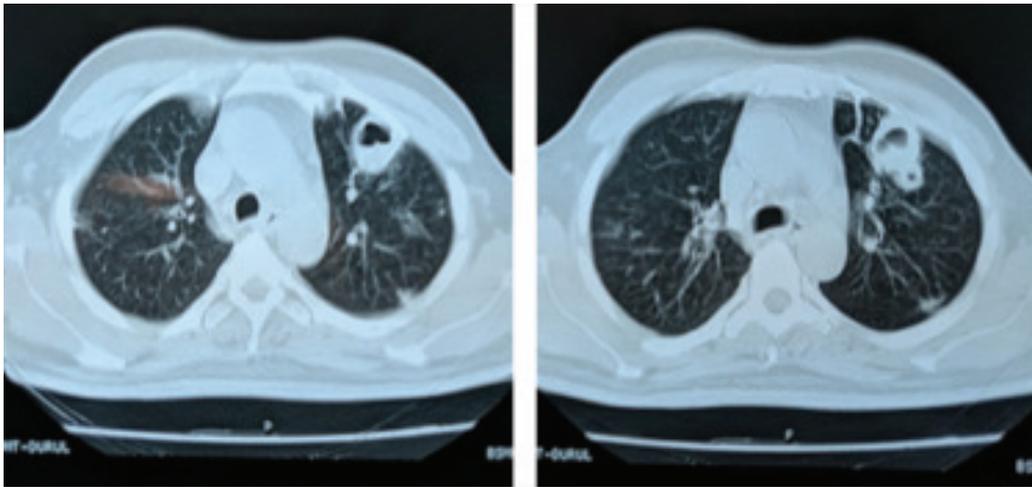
Contrast enhanced computed tomography (CT) scan of chest showing a thick walled cavity in the left side of the lung field
